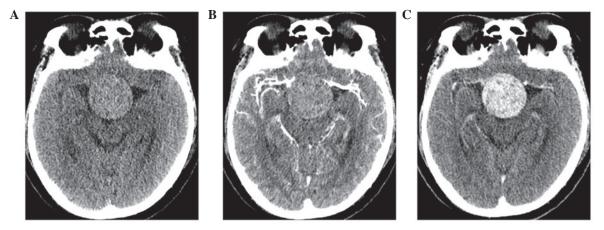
CT findings of intrasellar schwannoma. (A) Plain axial CT scan revealing a slightly hyperdense mass of the intra-suprasellar region. Following the administration of contrast agent, the mass shows heterogeneous enhancement at the (B) arterial phase and (C) venous phase. CT, computed tomography.
